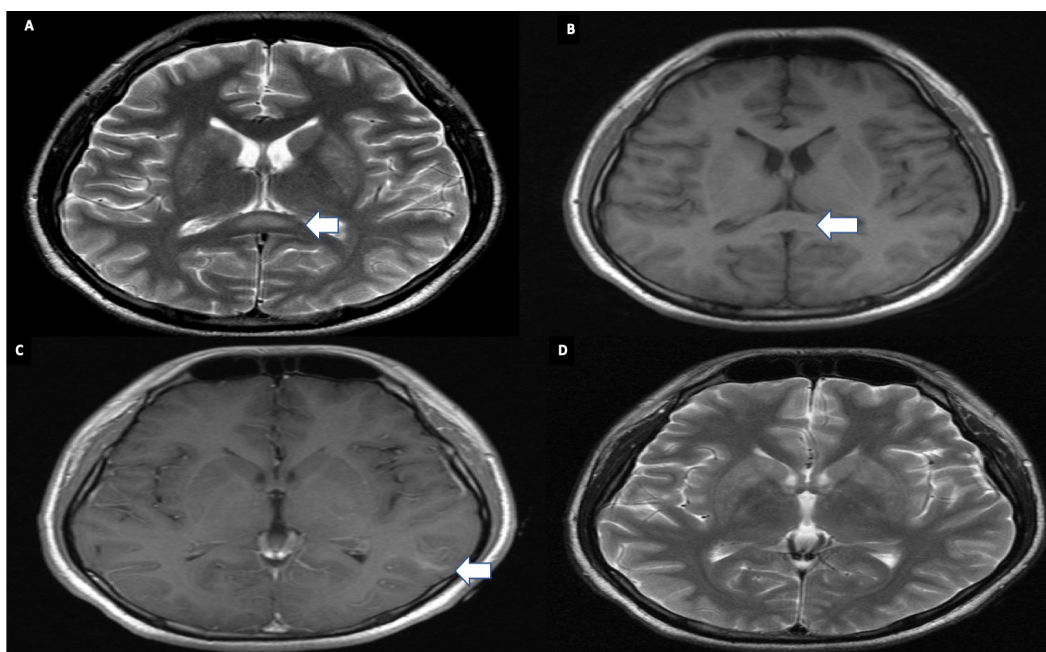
Magnetic resonance imaging of brain. Hyperintense and hypointense lesion in the splenium of the corpus callosum on T2-weighted image and T1 weighted images respectively (A, B). Focal enhancement noted at the subcortical white matter at the left parietal lobe noted on T1 post-gadolinium sequence but absent on T2-weighted image (C, D).
